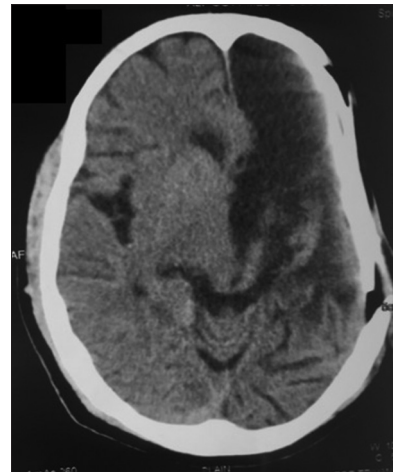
Computed tomography brain plain – Postcranioplasty after 1 year showing no residual abscess
